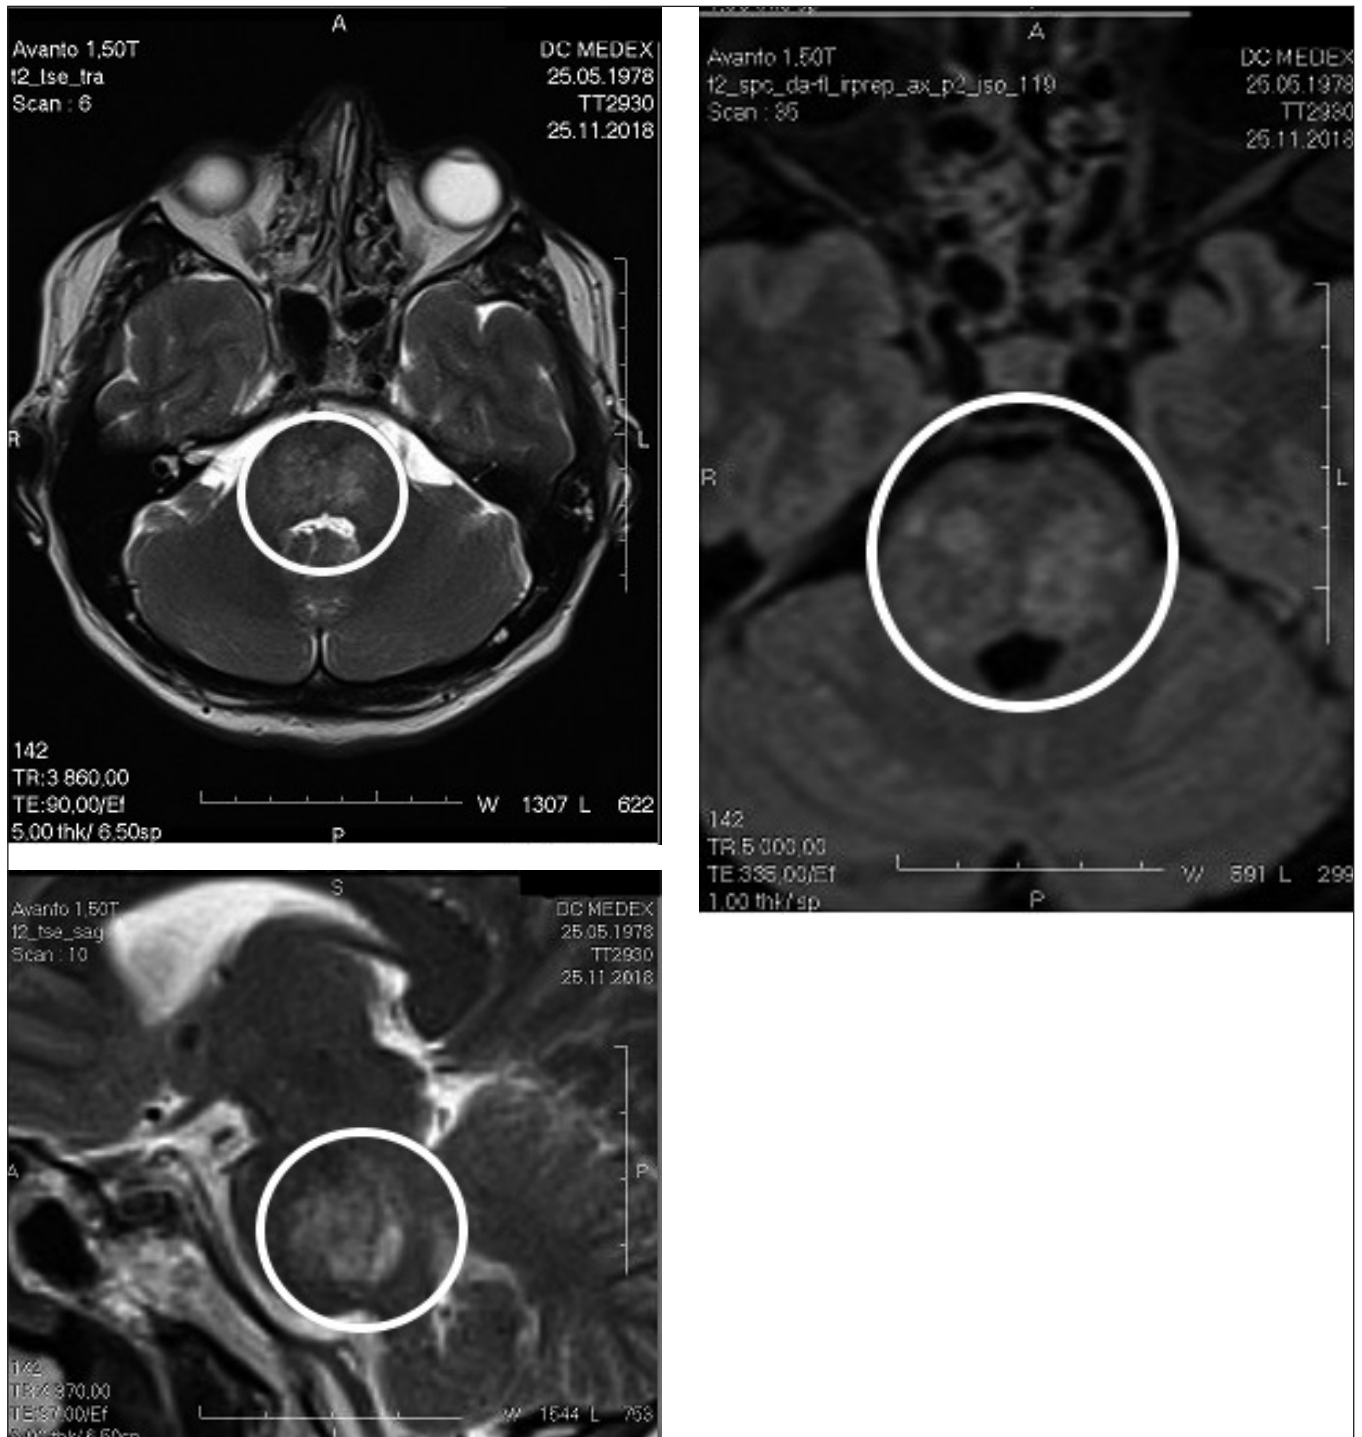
MR images of an inflammatory nature disorders in the pons with spreading to the upper and lower cerebellar peduncles without clear contours, a region of an amplified at T2 W1 signal has a total size of 22x47x28 mm.
